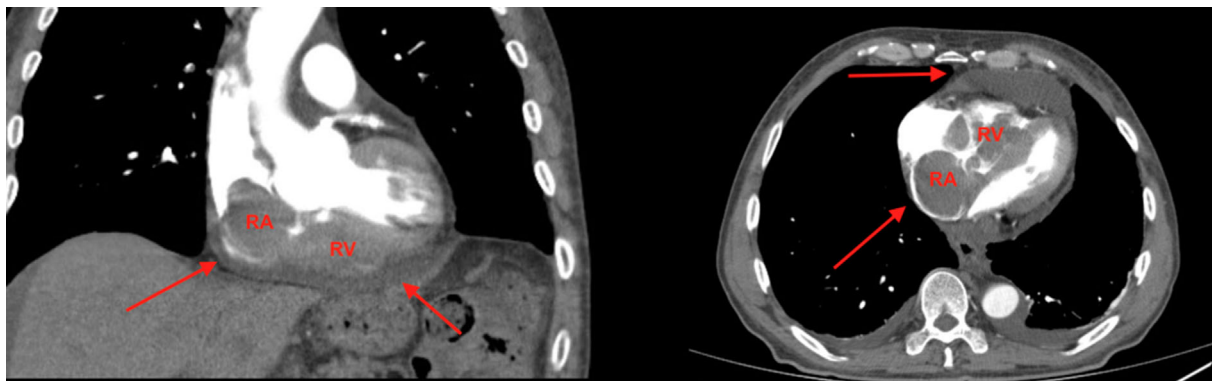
CT shows giant mass filling the atrium and ventricle (Coronal and axial plane)
